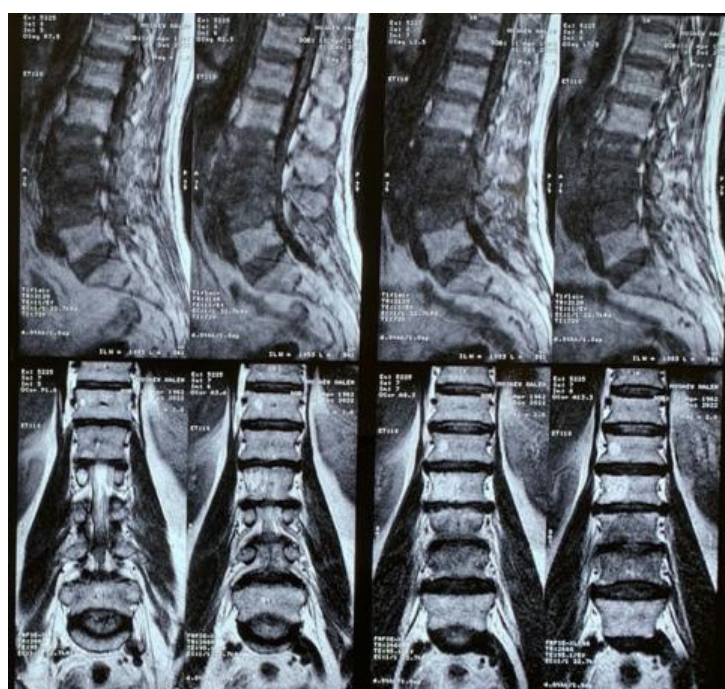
MRI image of patient No. 2. Signs of spondylodiscitis at the level of L3-L4 with the formation of an esophagus along the posterior contour of the L4 vertebra (brucellosis? tuberculosis?). Circular protrusion of the intervertebral discs L2-L3, L3-L4, L4-L5 with compression of the dural sac, narrowing of the intervertebral foramen. Hemangioma of bodies L1, L2 of the vertebrae;
